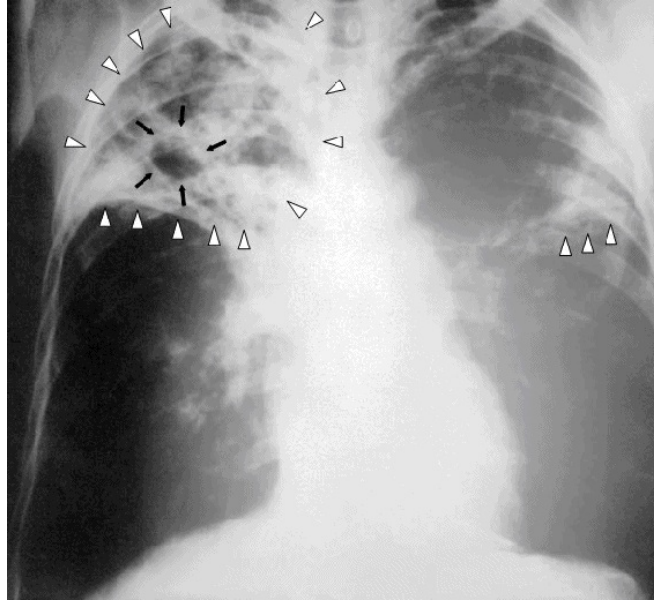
Tuberculosis X-ray
